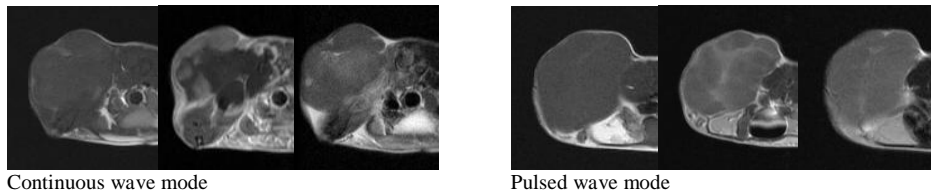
MRI of continuous and pulsed wave treated SCC tumors
